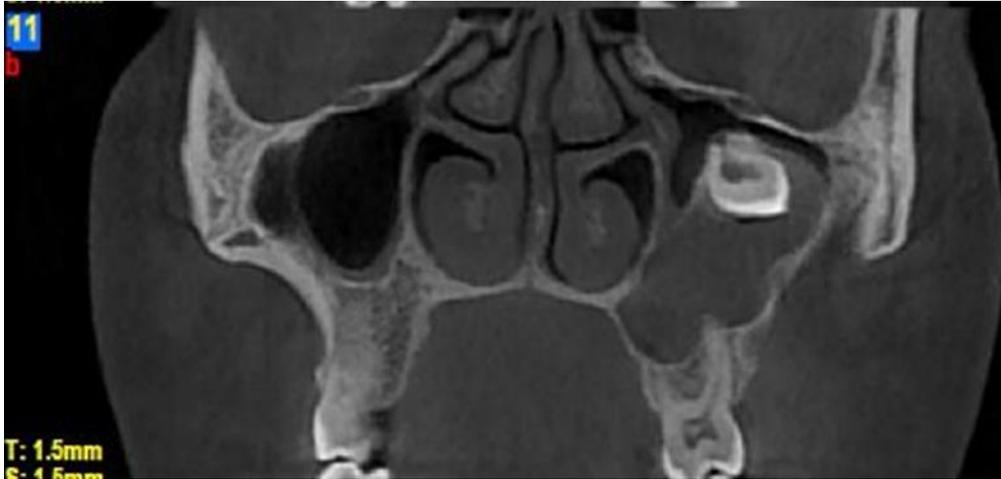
Coronal Section CT View Of Case 3
